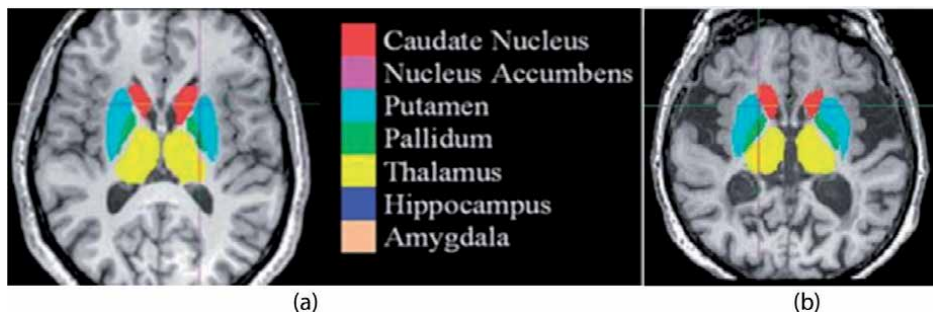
(a) and (b): subcortical segmentation of MRI scans, after boundary correction, of a subject classified as MCI (a) and of a subject diagnosed with probable Alzheimer's disease (b) (axial view) [26].
